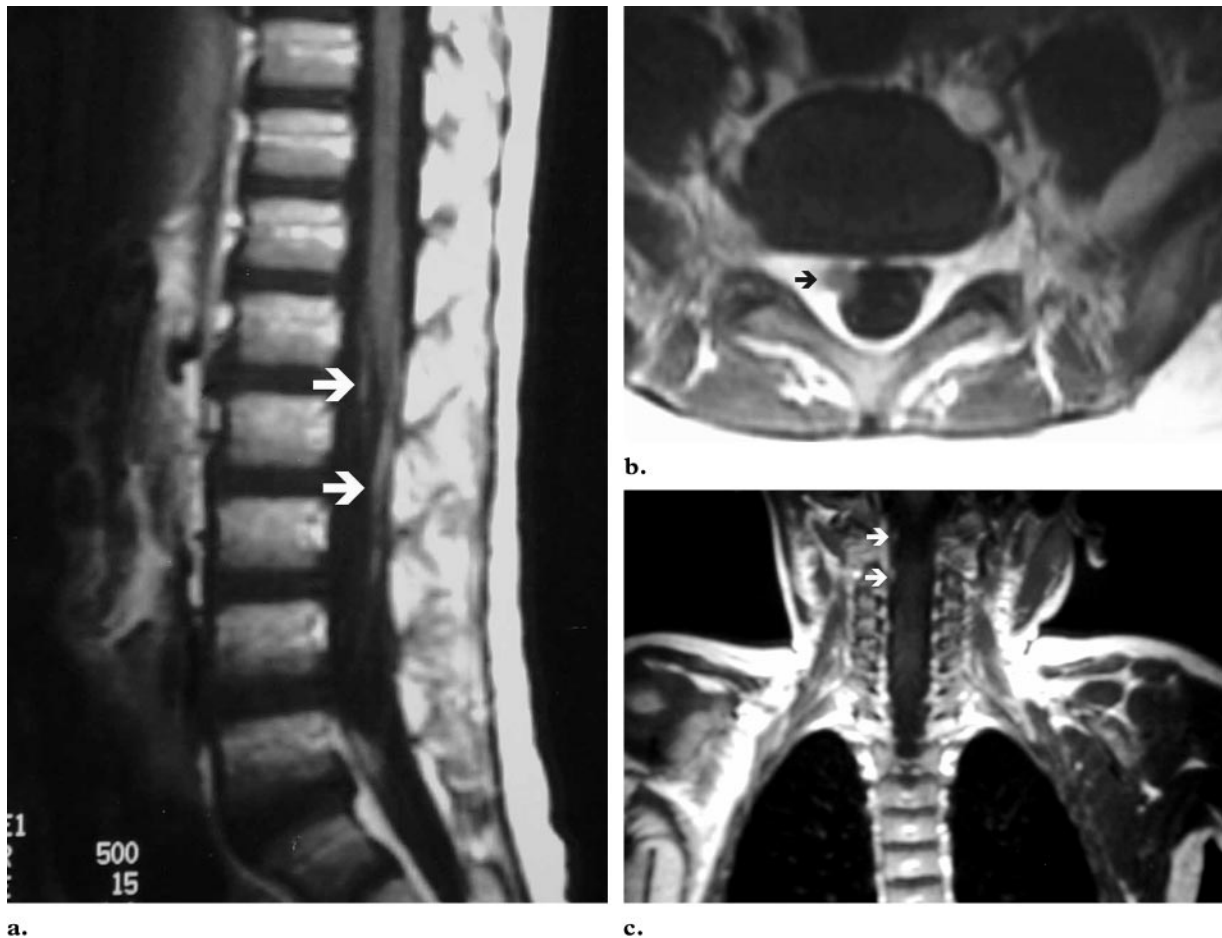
Leptomeningeal seeding by non-Hodgkin lymphoma in a 4-year-old boy with right arm and leg paresis who had been treated for primary abdominal Burkitt lymphoma. Sagittal (a) and axial (b) contrast-enhanced T1-weighted MR images of the lumbosacral region and coronal contrast-enhanced T1-weighted MR image of the cervical spinal cord (c) show multiple enhancing subarachnoid nodules (white arrows) with coating of the nerve roots on the right side (black arrow), findings consistent with leptomeningeal seeding. A lymphomatous leptomeningeal relapse was confirmed at cytologic examination of cerebrospinal fluid. Follow-up MR images obtained after treatment were normal.
